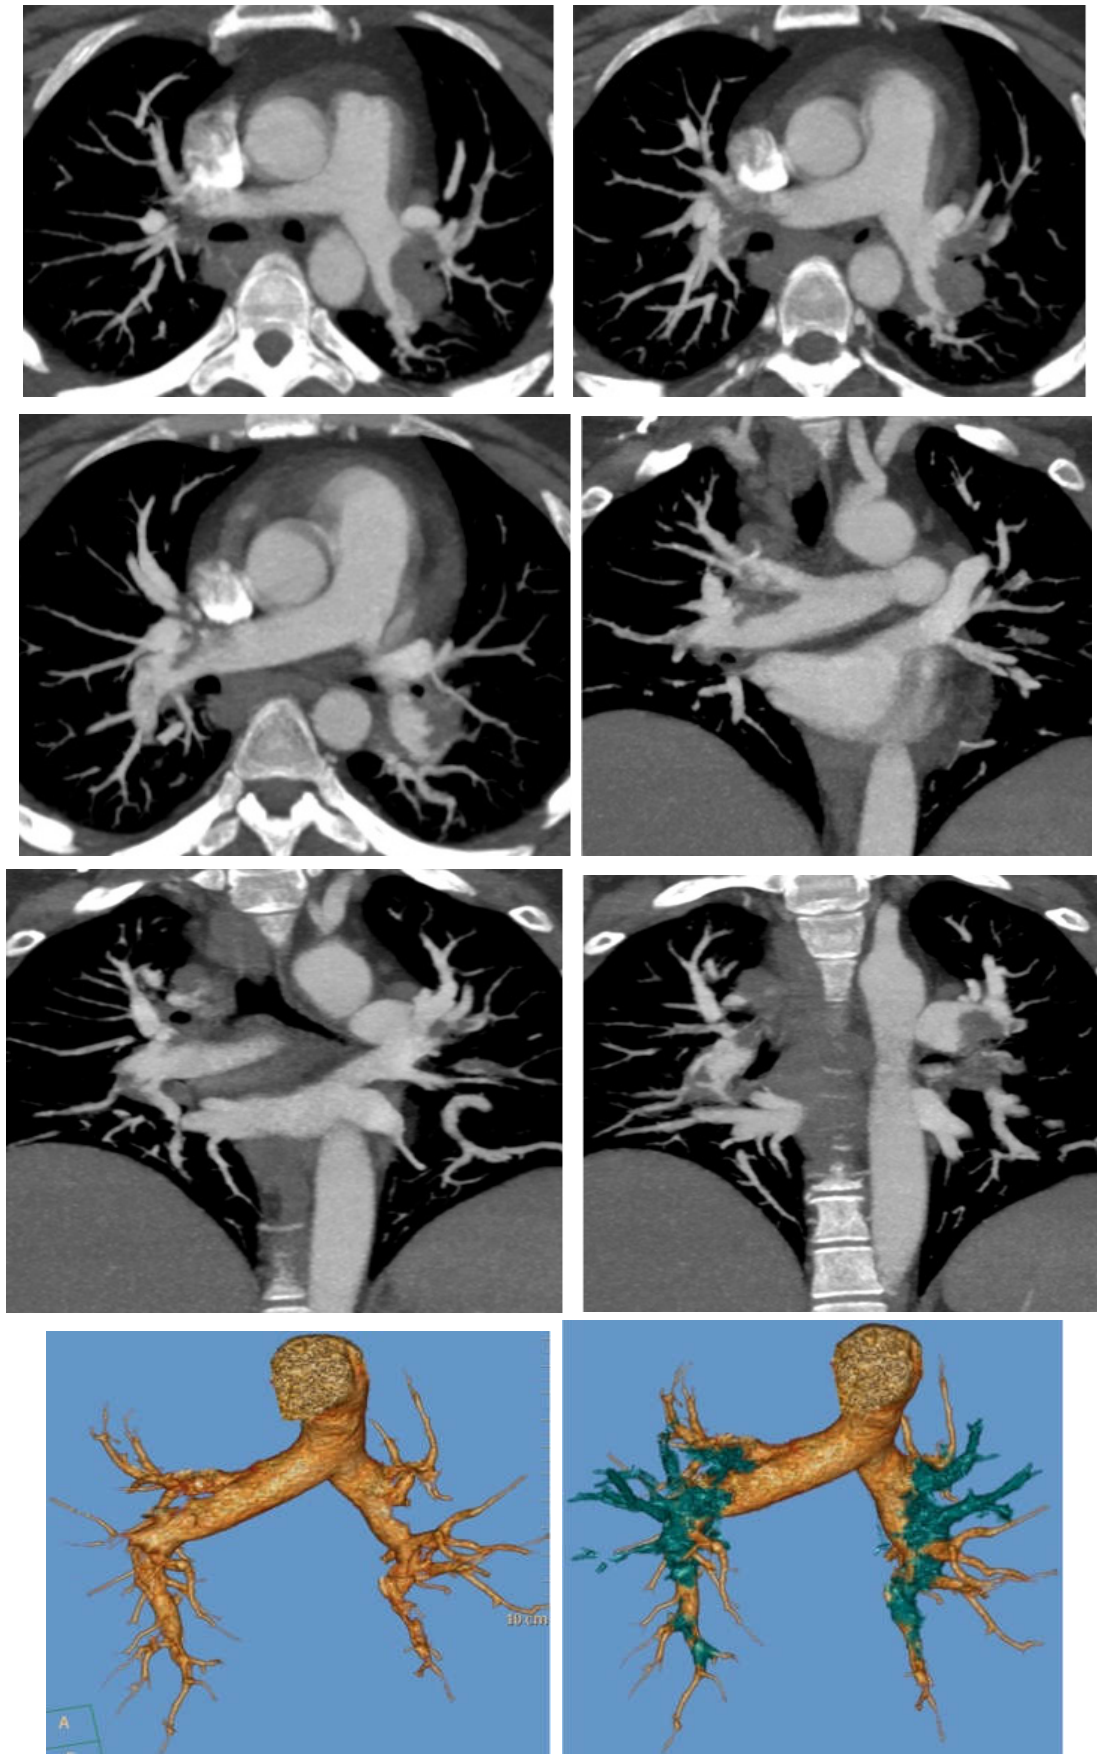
45 years old male with sudden onset of chest pain & breathlessness TRO CT Axial images (a,b,c,d,e,f),coronal images (g,h,i), sagittal images (j,k,l)&MIP axial, coronal & sagittal pulmonary tree images (o,p,q,r,s,t) reveal Bilateral massive pulmonary embolism with saddle thrombus at bifurcation
